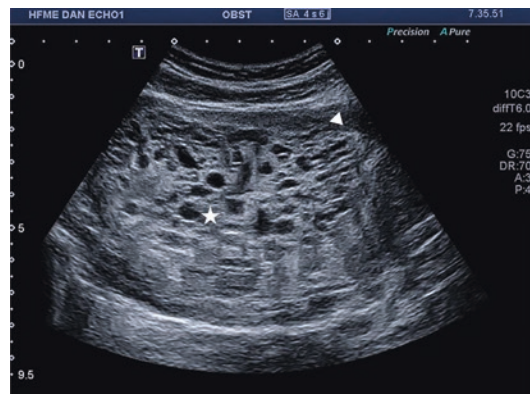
Pelvic ultrasound of a patient with an intrauterine complete hydatidiform mole at 4 weeks of gestation +6 days. Triangle indicates the healthy myometrium and the star indicates some echogenic structure of the molar tissue
